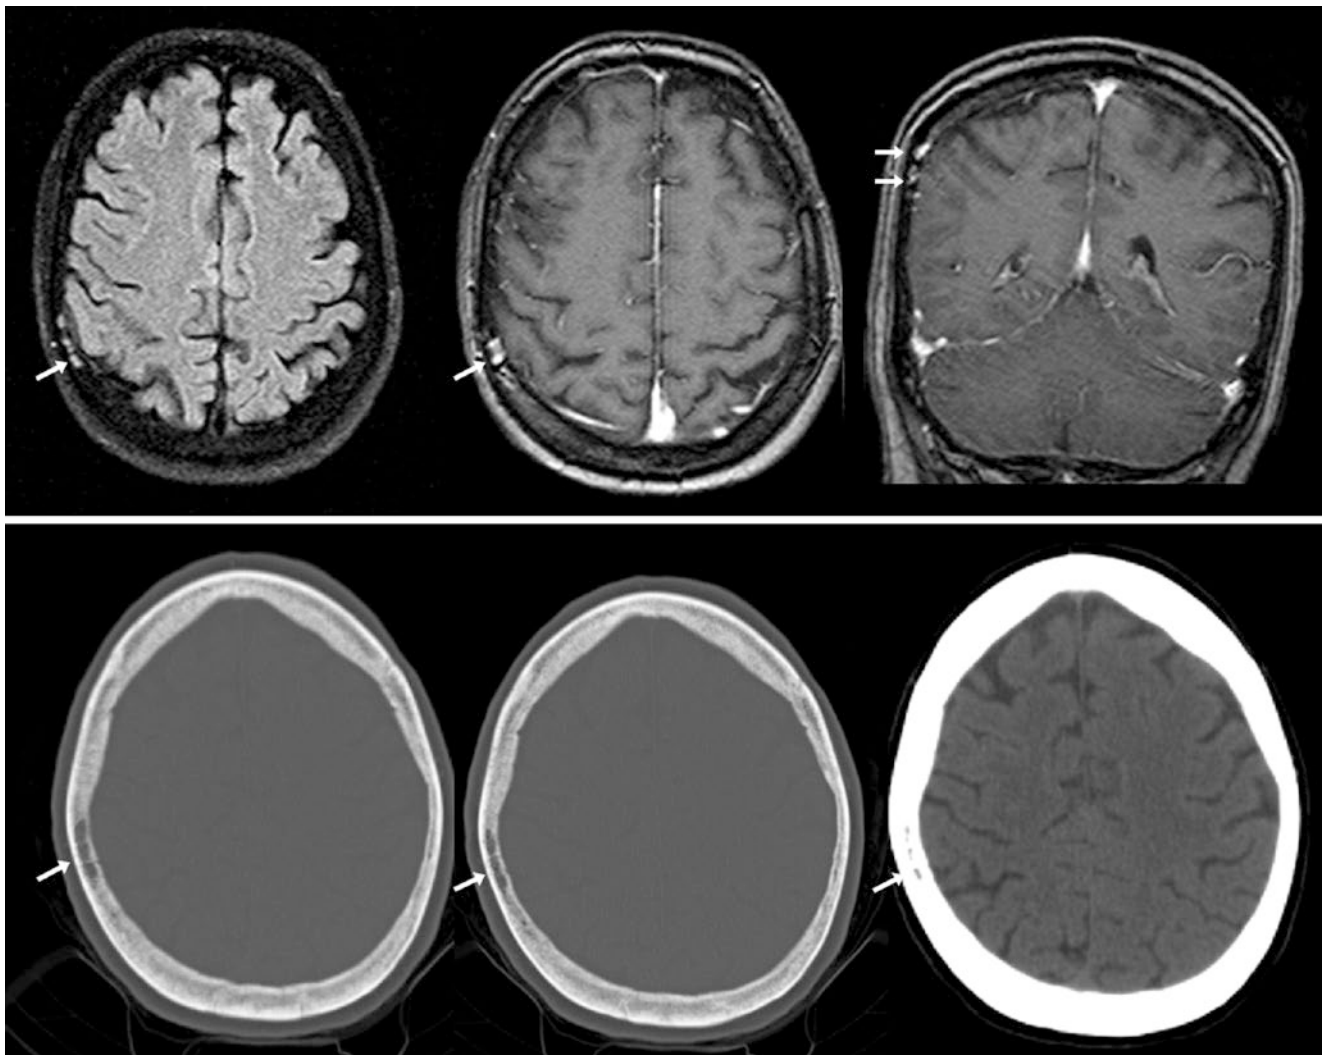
A 57 year old: on noncontrast fat-suppressed FLAIR (*top left*), a focus enhances after IV contrast on both axial and coronal T1WI (*top middle and right*). This venous channel (*bottom*) is confirmed on CT by scrolling axial images (*bottom*) to verify a linear, connected appearance
